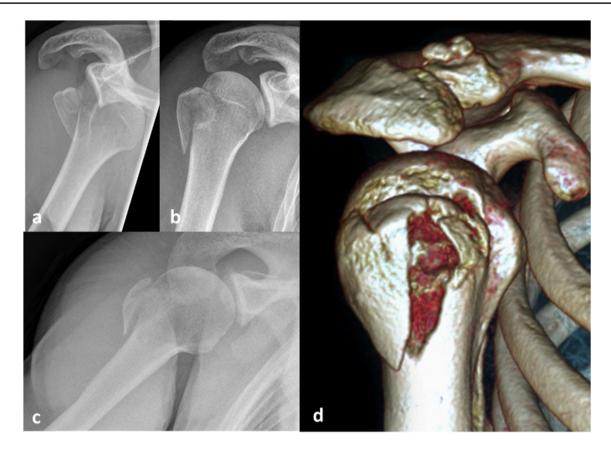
A 38-year-old highly active anesthetist sustained an isolated, posteriorly displaced split fracture (Mutch type 2) of the greater tuberosity. X-ray of the right shoulder in the AP view before (\mathbf{a}) and after (\mathbf{b}) closed reduction, and axillary view (\mathbf{c}). CT scan after reposition (\mathbf{d})
